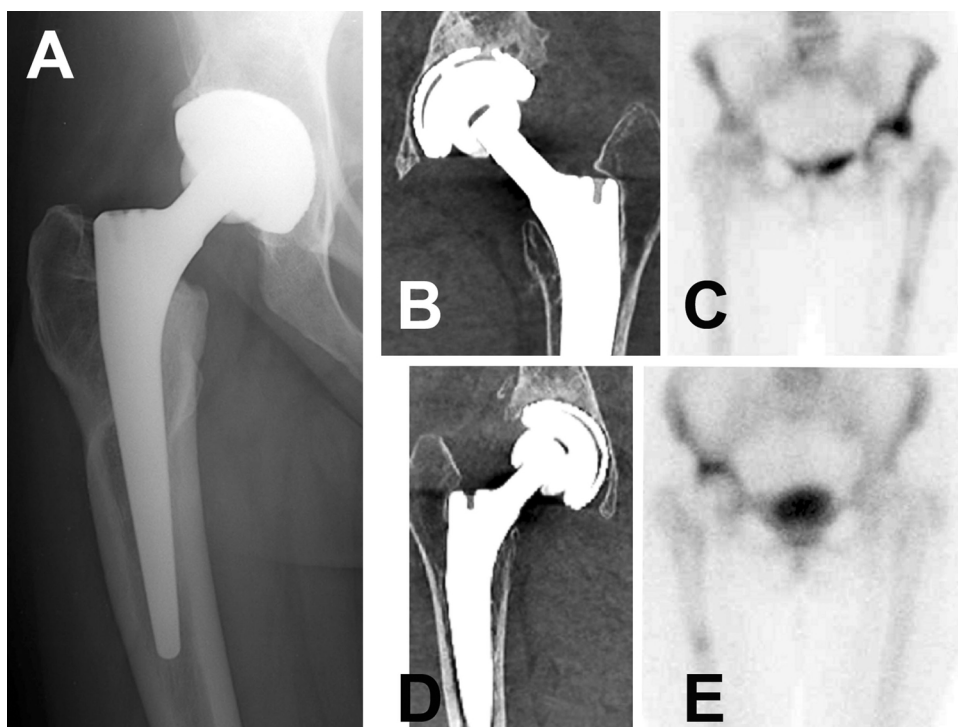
X-ray analysis of the three patients with aseptic loosening of an alumina-on alumina prosthesis. A) Patient #1 with anteversion of the femoral stem. B–C) Patient #2 CTscan showing an aseptic loosening and ⁹⁹Tc-MBP scintigraphy showing increased fixation in the iliac bone. D–E) Patient #3 with similar signs on the CTscan and scintigraphy.
